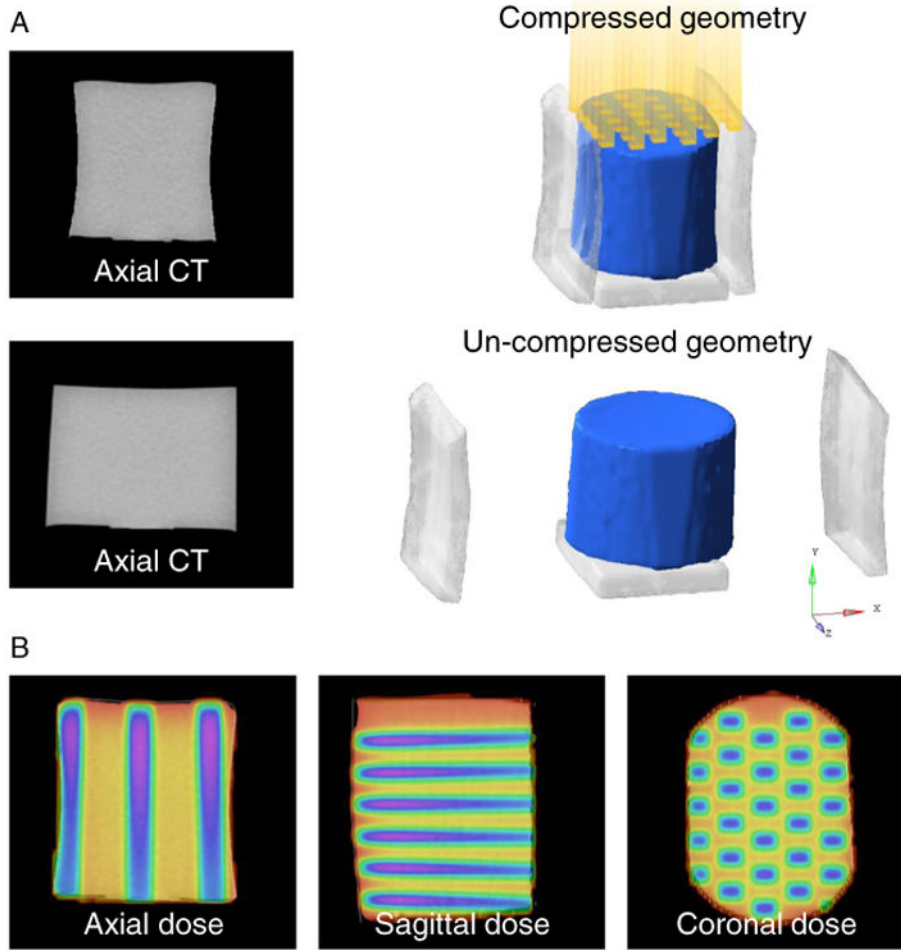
(A) Three-dimensional dosimeter models were generated with and without compression from corresponding computed tomography (CT) images (the plates were digitally removed). The yellow columns show the incident radiation beams. (B) The dose distribution was planned in the dosimeter's compressed geometry. (Color version available online at www.practicalradonc.org).
